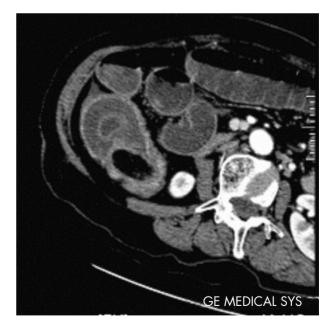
Abdominal CT of the ascending colon.
